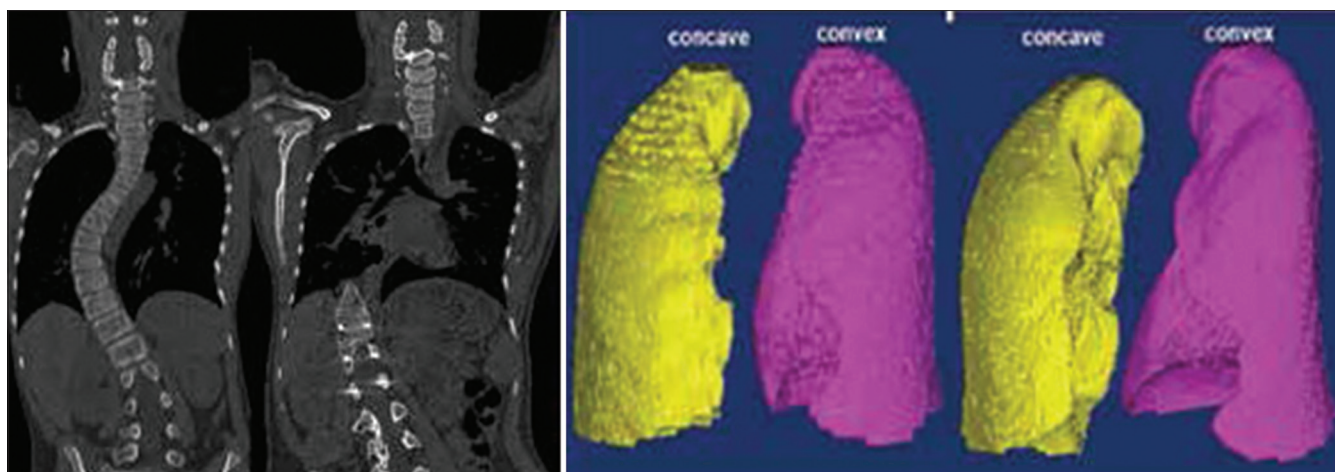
Five years postoperative truncal change (2009–2014). Computed tomography taken in 2009 and 2014 for the measurement of change in truncal height and lung volume. Truncal height measured from the center of T1 to T12 improved from 146 mm to 203 mm, showing 28% improvement. The lung volume increased by 33% at concave side and by 34% at convex side
